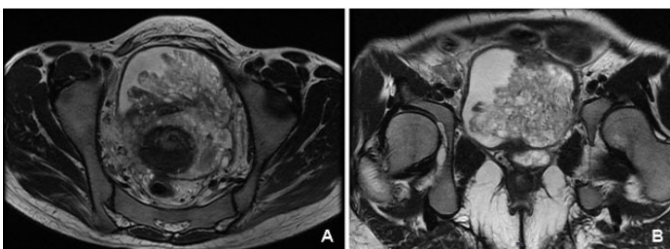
MRI images showing endometrial tissue occupying the whole bladder and infiltrating it.
